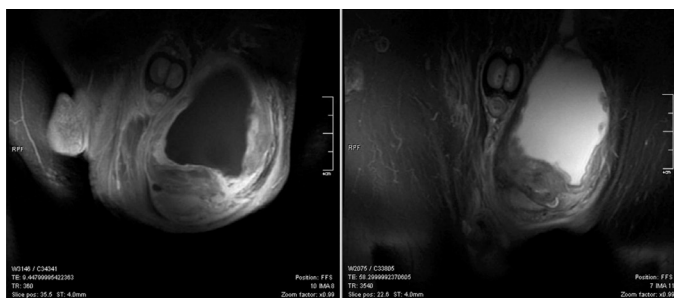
Magnetic resonance imaging coronal section views of scrotum showing 48x60x81 mm minimally heterogeneous contrast enhanced lesion with medially large cystic cavity fulfilling the left hemiscrotum suggesting infected epididymal cyst or intrascrotal abscess related lesion (on the left side) T1 weighted image; (on the right side) T2 weighted image
